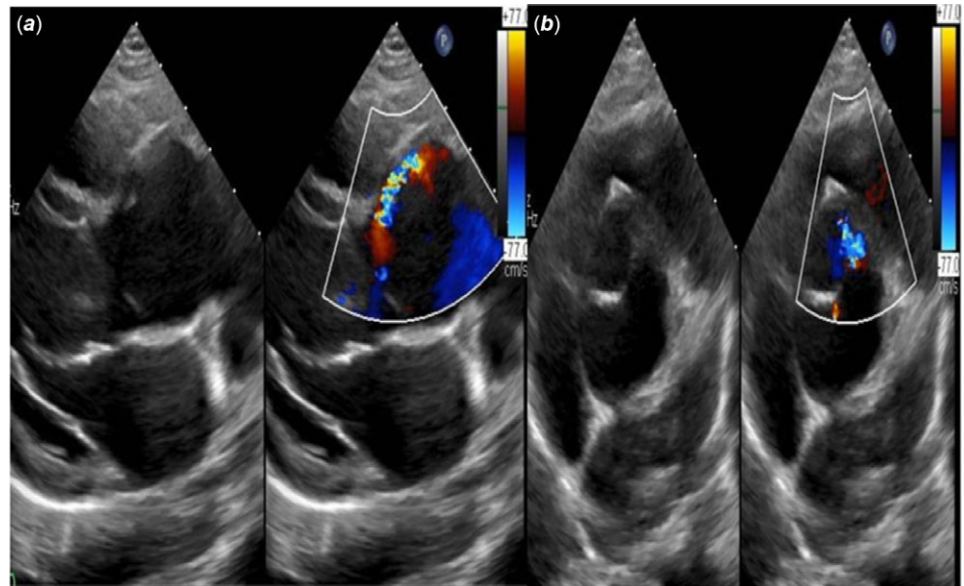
Transthoracic echocardiography depicting the aorto-left ventricular tunnel.
